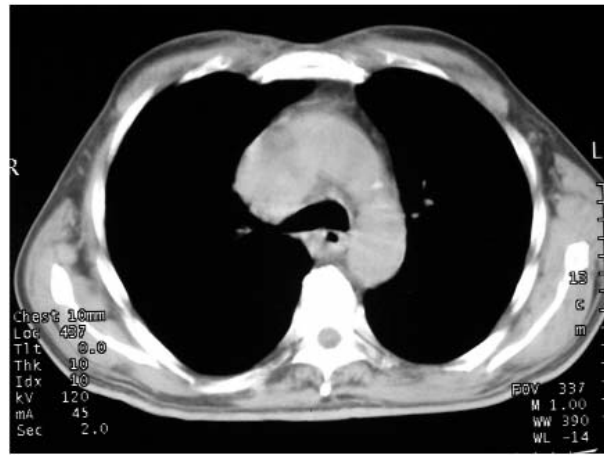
Computed tomography shows mediastinal extension of the gland.
